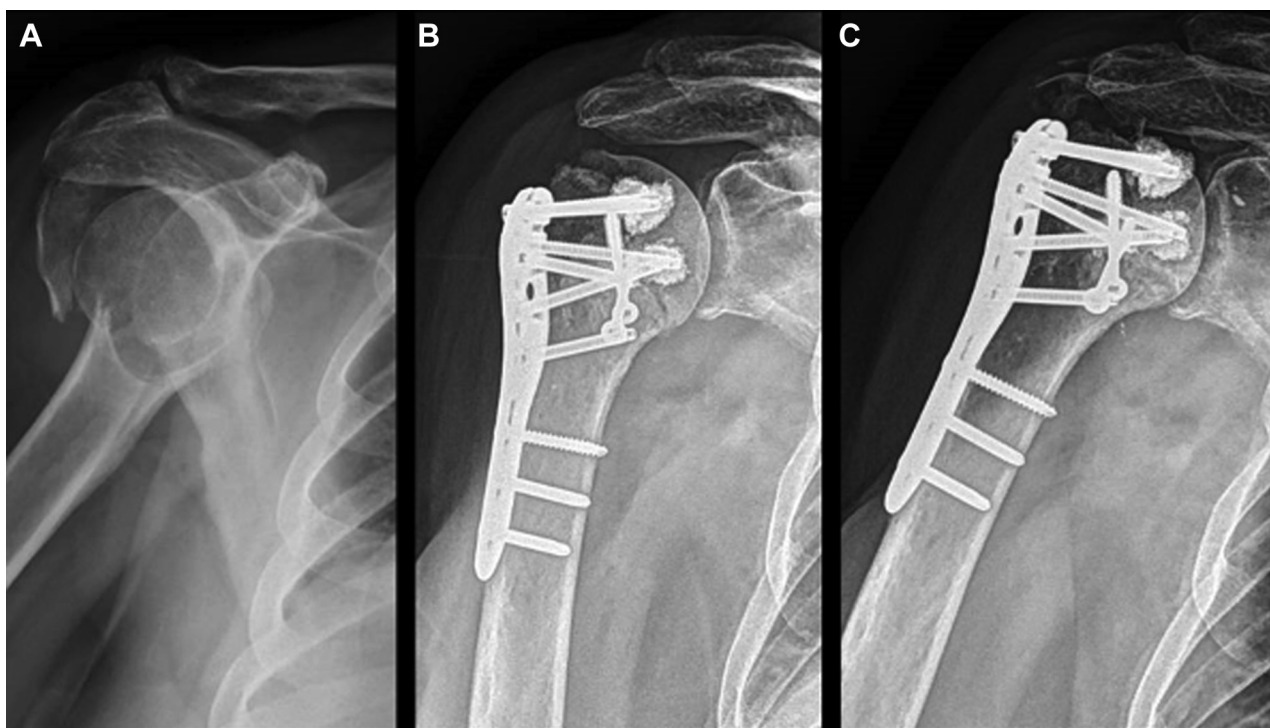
Partial avascular necrosis after ORIF with screw tip augmentation. (A) Preoperative x-ray. (B) Postoperative anteroposterior shoulder view. (C) Partial avascular necrosis proximally to the most cranial screws. ORIF, open reduction and internal fixation.
